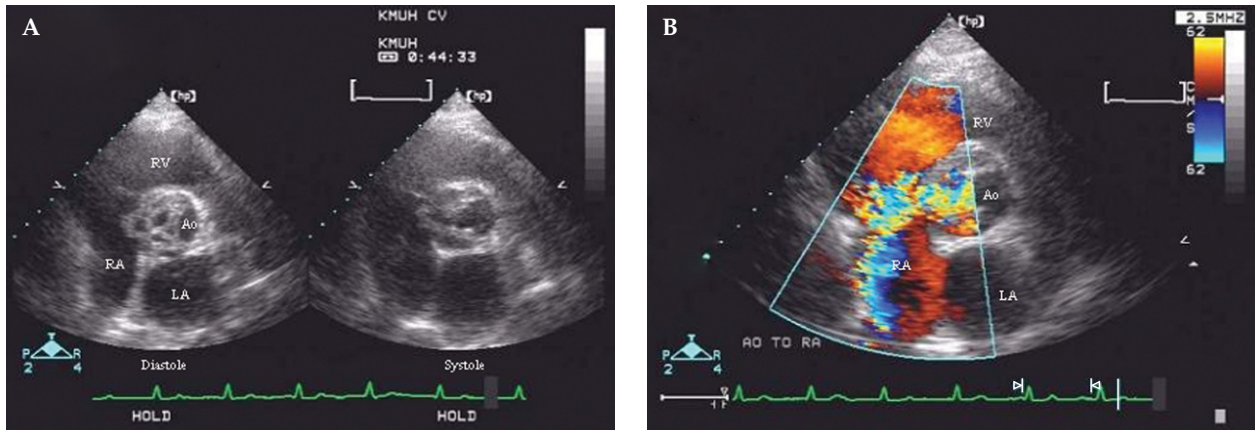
(A) Parasternal short-axis view at the aortic valve plane on 2-D echocardiography. Prolapse of mycotic aneurysm with a small disruption in the aortoseptal continuity are demonstrated. Also note that the orifice surrounded by three destroyed aortic semi-lunar valves remained open during diastole. (B) Color Doppler echocardiography reveals turbulent flow through the ruptured non-coronary sinus of Valsalva, with blood flowing from the aortic root into the right atrium.
